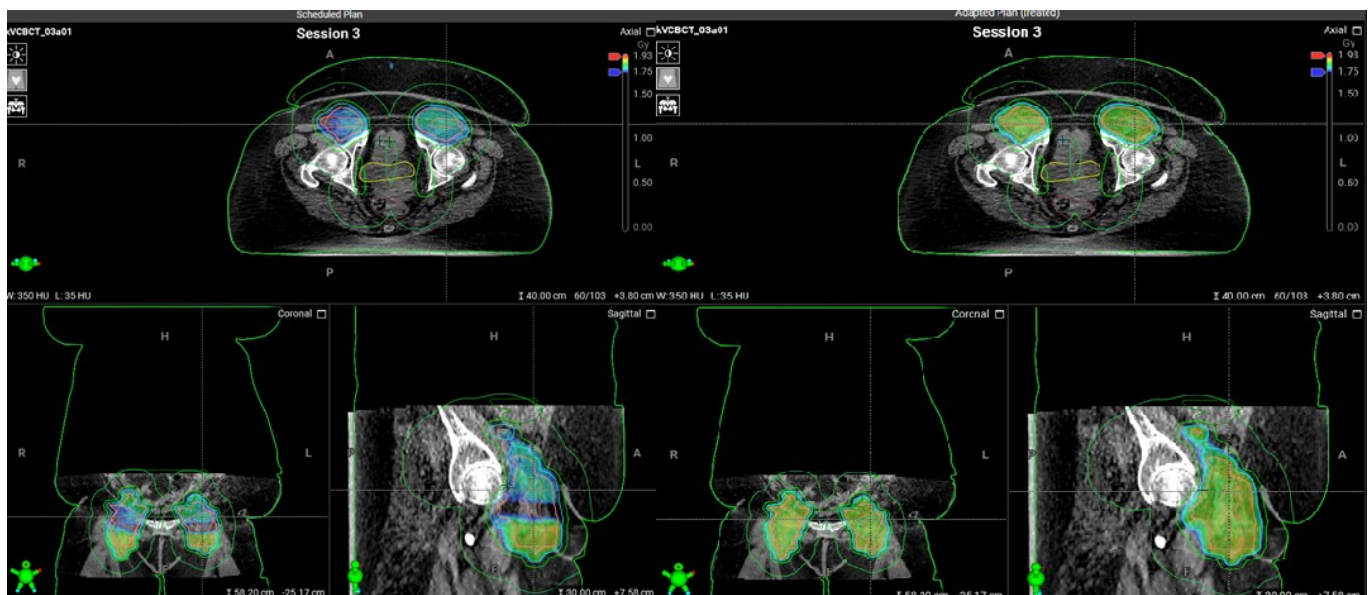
Example of patient with big anatomical change (abdomen hangs lower than on planning CT) causing scheduled plan to not cover target. By having the adaptive plan as an option, dose to target could be achieved.
